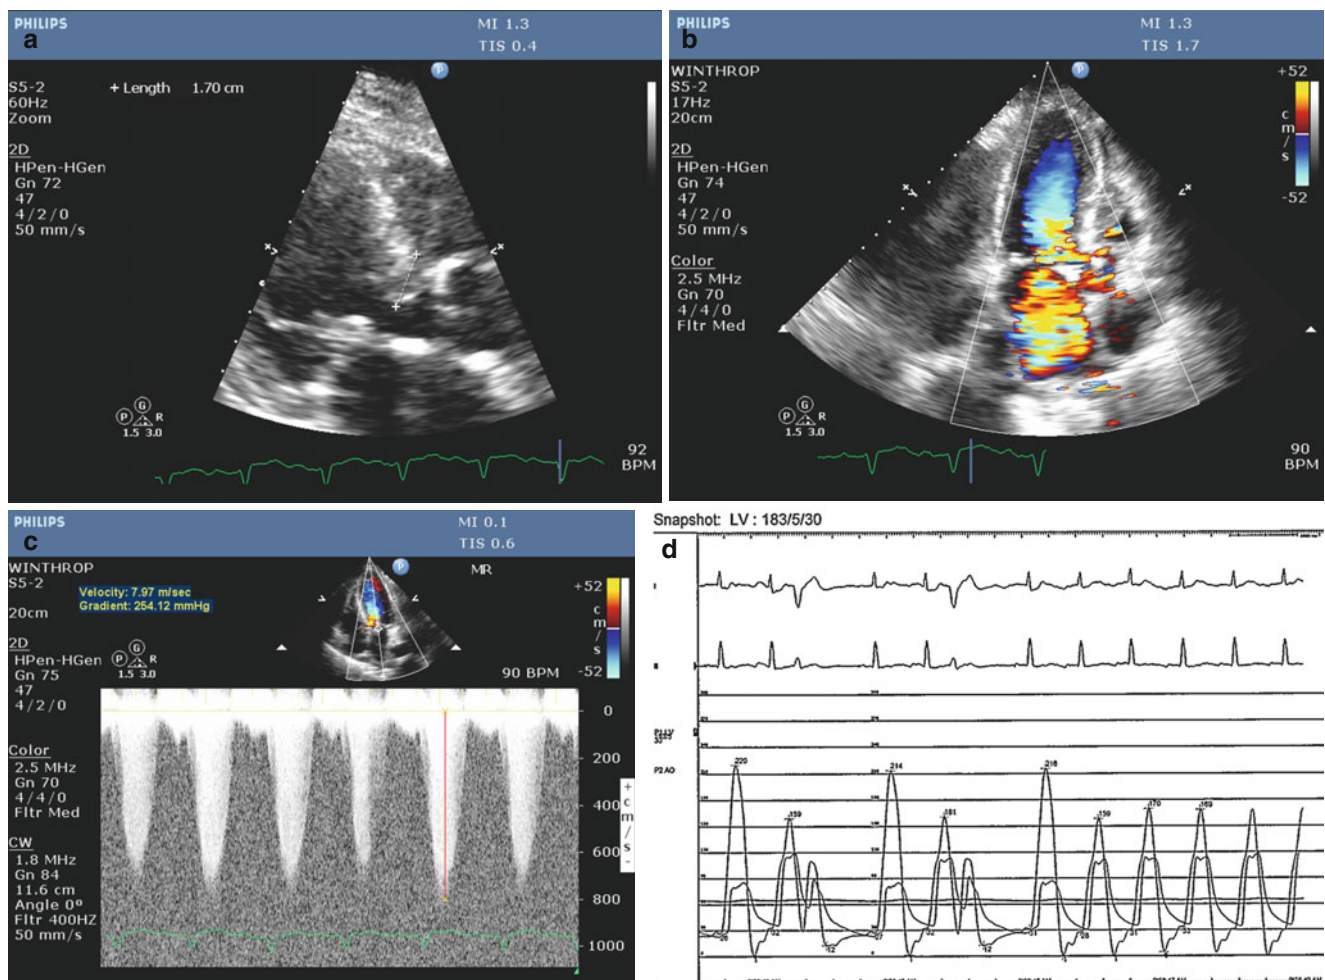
Case 4: Measurements on presentation. (a) TTE parasternal long axis view depicting asymmetric septal hypertrophy, (b) TTE 3-chamber view depicting severe mitral regurgitation, (c) spectral Doppler
